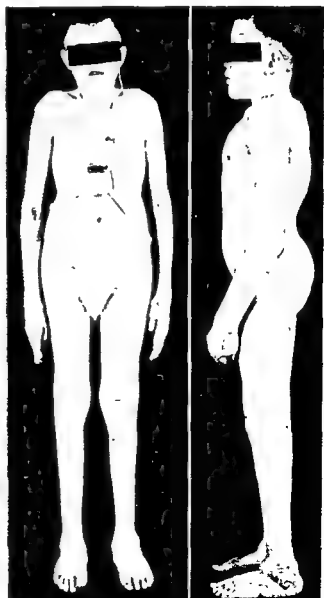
The patient whose roentgenograms are shown in Figures 4, 5 and 7. The reason for this patient's wearing a hearing aid is not known to the author. Deafness is common in gargylism but not in Morquio's disease. (Patient of Dr. A. DePalma, Philadelphia)
